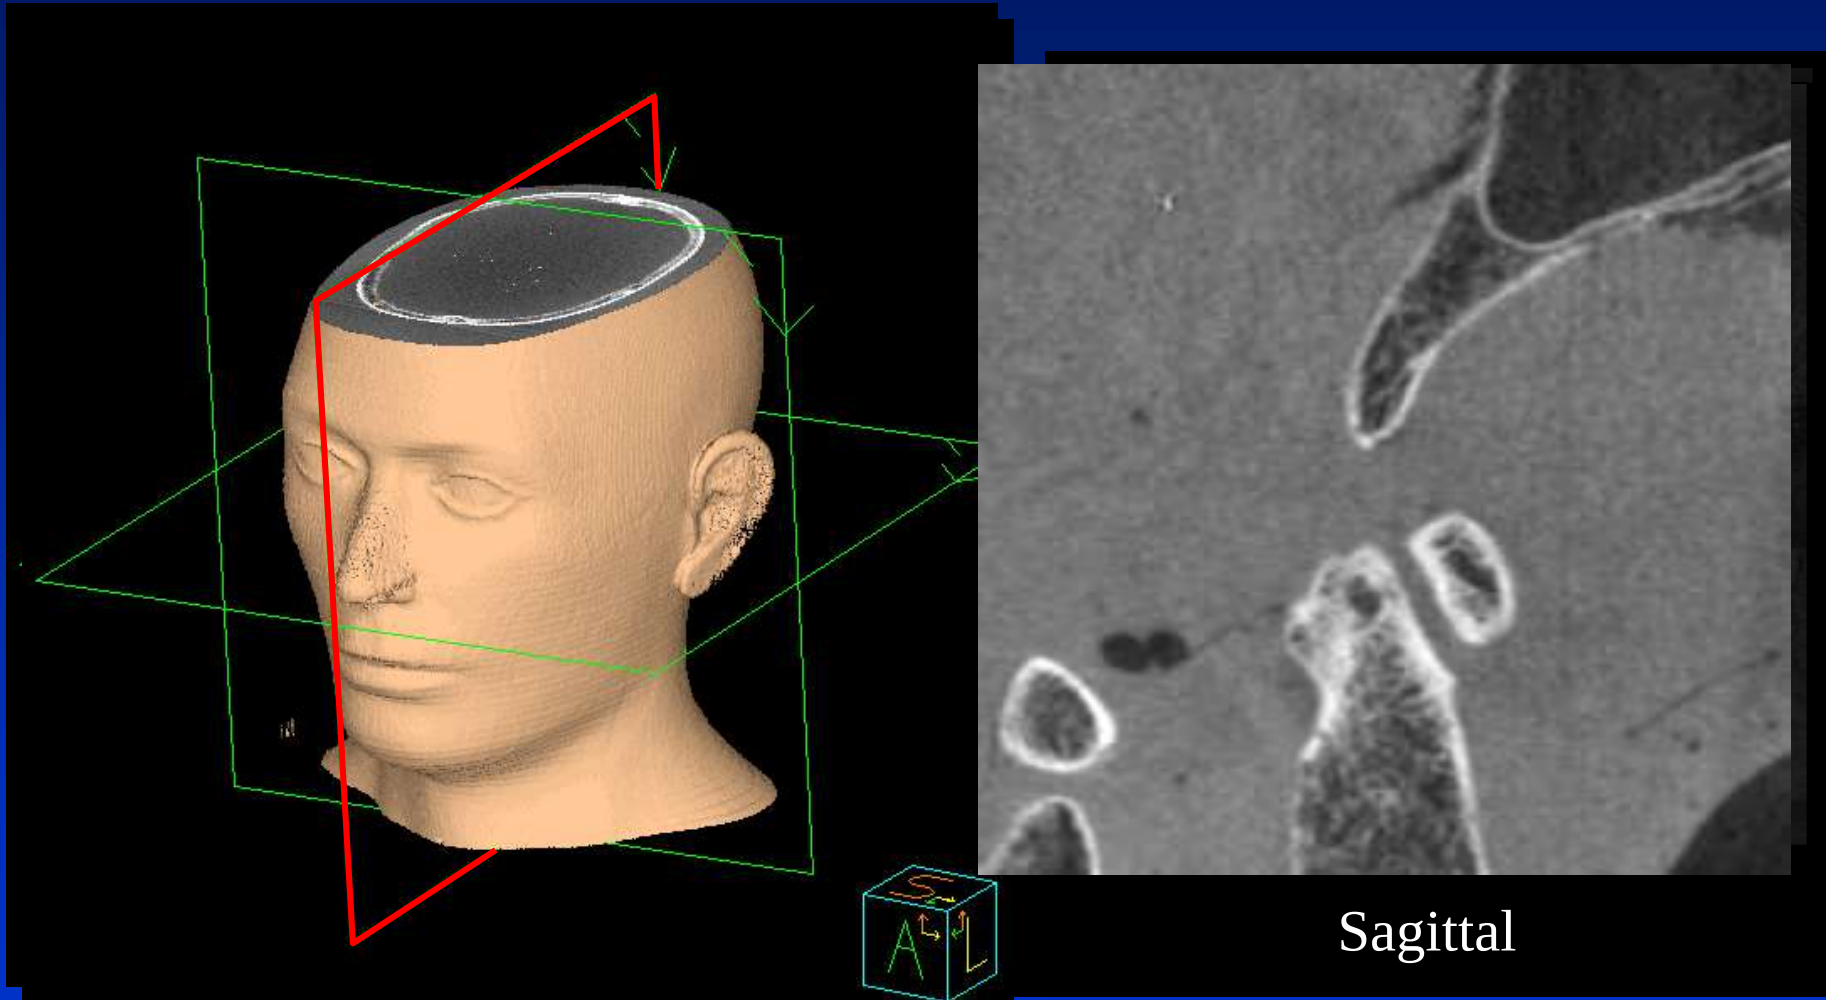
Image-Guided RT: Platform Cone Beam CT
